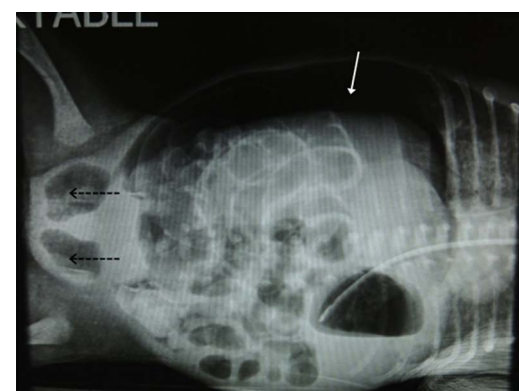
Left decubitus abdominal radiograph showing the presence of free intraperitoneal air outlining the right lateral abdominal wall (solid white arrow). Rigler's sign (dashed white arrows) and air in the scrotum (dashed black arrows).
